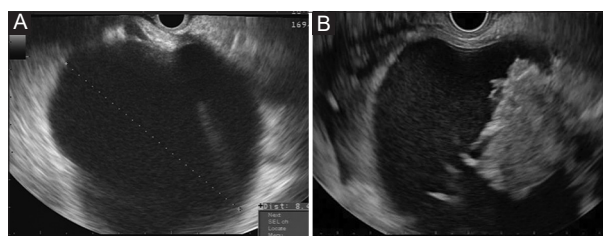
Endoscopic ultrasound imaging of pancreatic cyst without solid debris (A) and pancreatic walled-off necrosis with necrotic debris within the cyst cavity (B)
